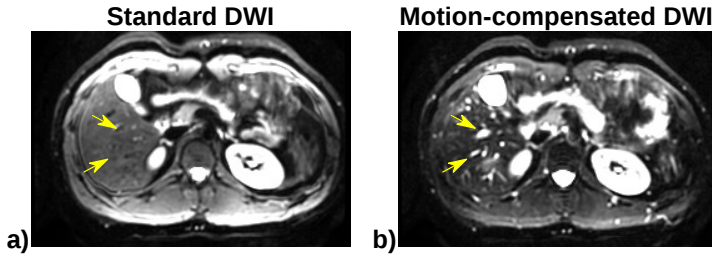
Diffusion-weighted images of a standard DWI acquisition (a) and a motion-compensated DWI acquisition with gradient moment-nulling (b). b-Value of both DW images is  $100 \text{ s/mm}^2$ . Yellow arrows point at blood vessels which show suppressed and unsuppressed signals on the standard and on the motion-compensated images, respectively.
